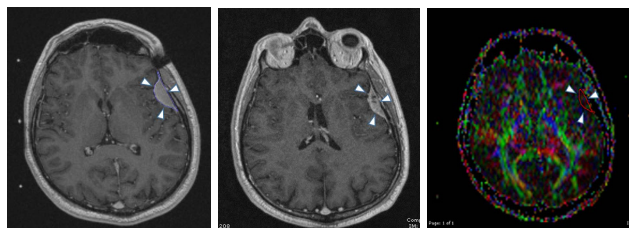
Left frontal meningioma. Analysis of total tumor volume (TTV) using by the placement of a region of interest (ROI) on post-contrast 3D T1-weighted axial image (arrowheads) (a). A significant decrease in TTV is observed after 48 months follow-up after radiosurgery (arrowheads) (b). MD, RD, and FA values were calculated by placing ROI that covers the tumor completely in FA maps (arrowheads) (c). (A higher resolution / colour version of this figure is available in the electronic copy of the article).
